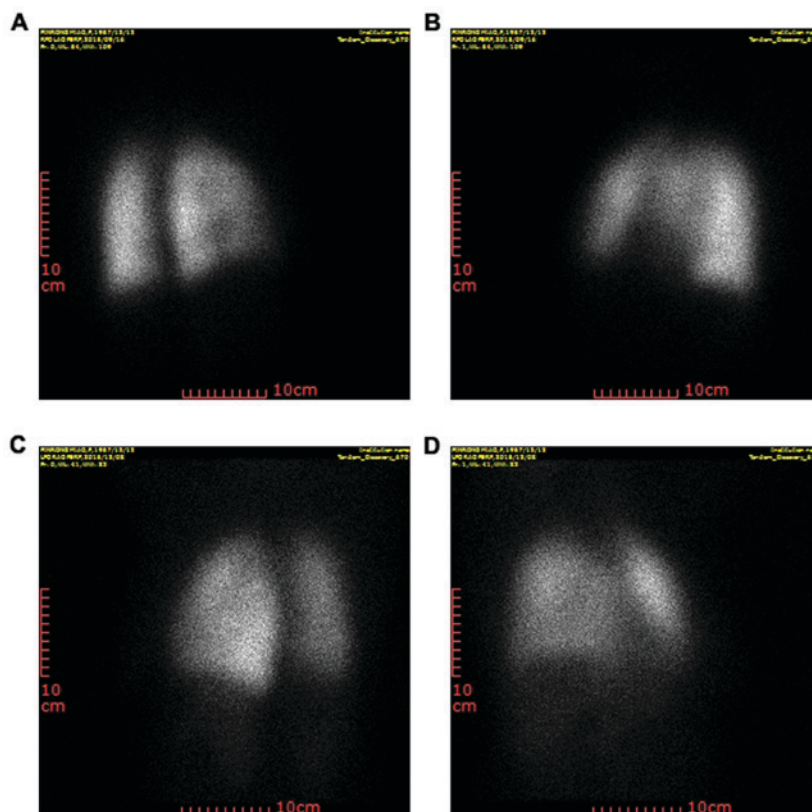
Single-photon emission computed tomography images of patients. (A and B) Representative images of non-small cell lung cancer patients without RP prior to radiotherapy. (C and D) Images obtained after stereotactic body radiation therapy, displaying RP with ground-glass opacity changes and irregular enhancement in the lung (scale bars, 10 cm). All images were obtained from different patients. RP, radiation pneumonitis.
